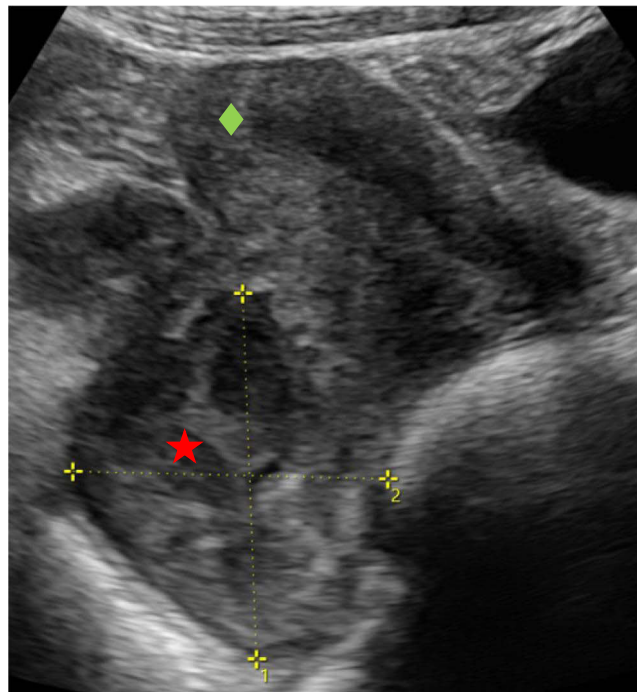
Transabdominal ultrasound showing the ventrally lying uterus (green diamond) with an inhomogeneous tumor (red star) directly adjacent to the posterior uterine wall in the pouch of Douglas. The tumor seems to be tightly adherent to the uterus.
